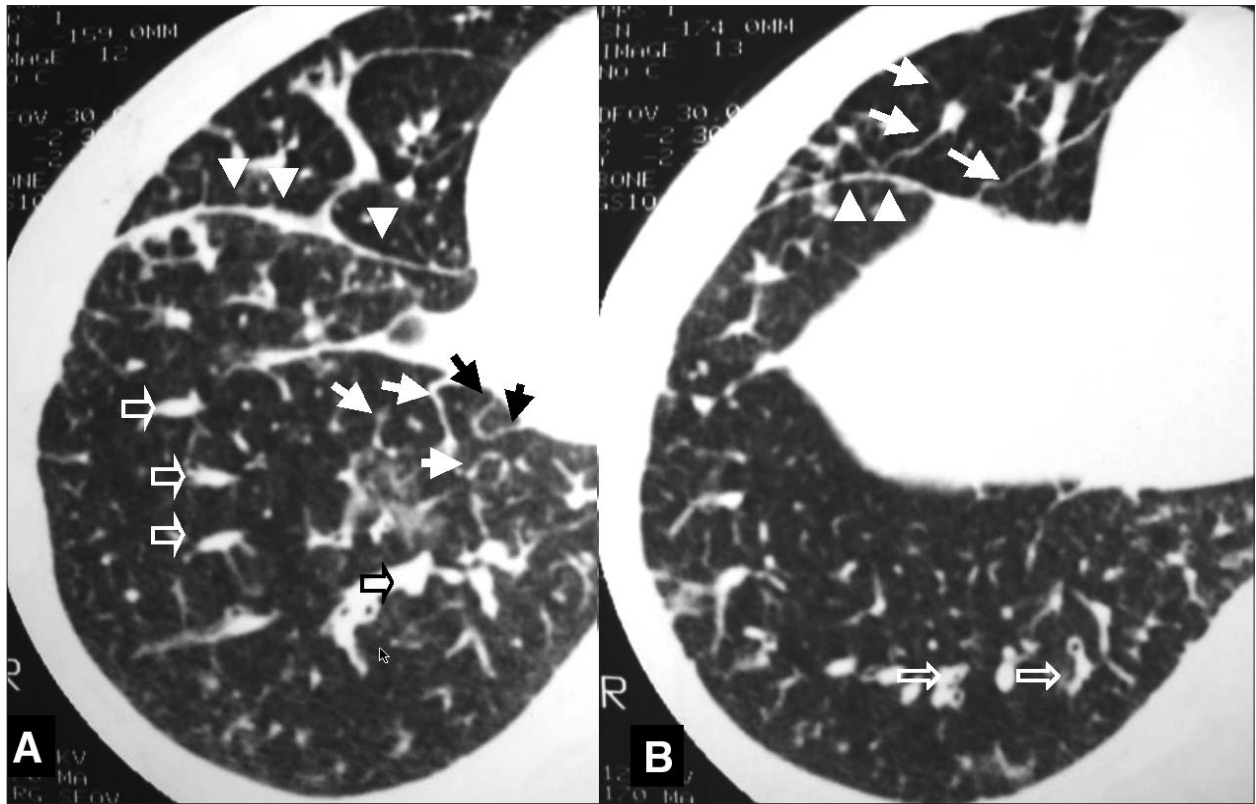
A, B. - HRCT slices at the lower lung zones demonstrate diffuse bronchial wall thickening, marked dilatation of the intrapulmonary branches of the pulmonary veins (open arrows), and thickening of the fissures (arrow heads). Smooth thickening of the interlobular septa is seen in some areas (solid arrows) associated with areas of ground glass opacities.
